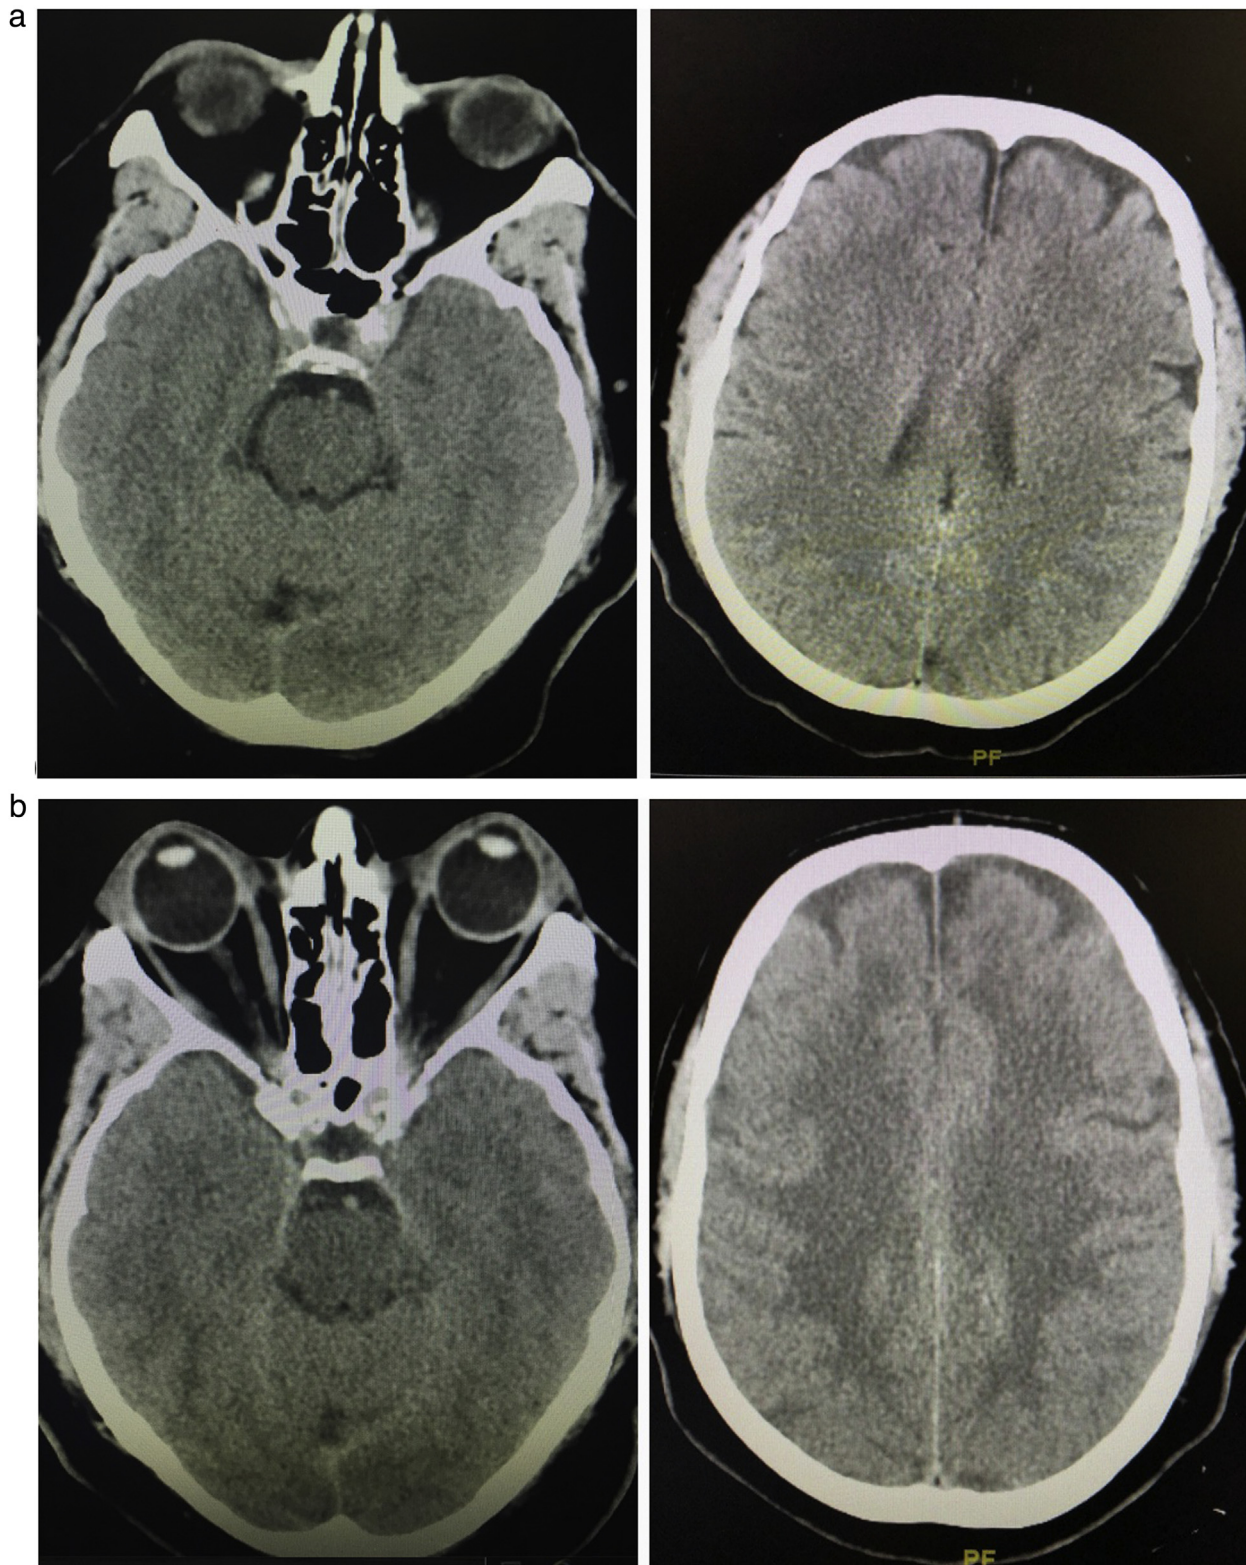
CT brain on admission (a) and 4 h later with significant increase of swelling (b).
